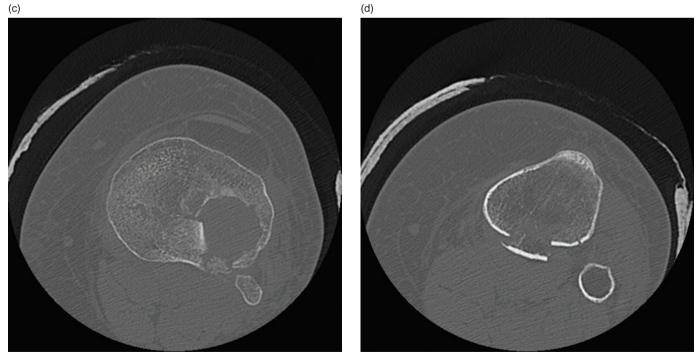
AP (a) and lateral (b) radiographs of complex tibial plateau fracture in an obese middle-aged patient. (c–f) CT of knee in bone window in axial (c, d), sagittal (e) and coronal (f) reformations. (g, h) AP (g) and lateral (h) postoperative radiographs showing dual plating of tibial plateau fracture
